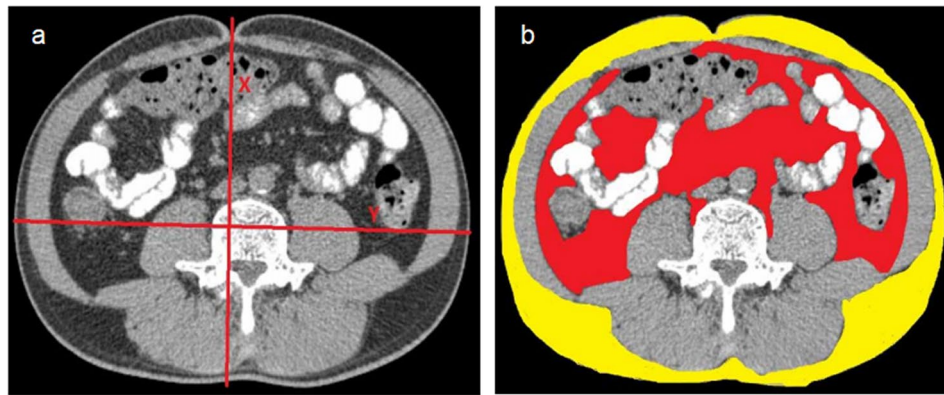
CT umbilical plane axial position. X: transverse diameter of abdomen, Y: anteroposterior diameter, VFA is red area
